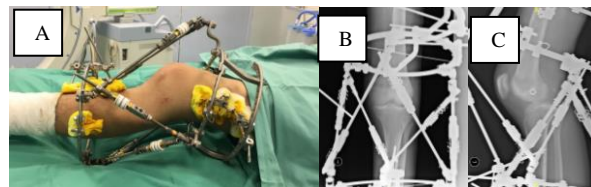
Post operative knee photograph and plain radiographs of one of the patients. (A) Ortho-SUV frame applied in-situ across the dislocated knee. (B) AP view and (C) lateral view plain radiographs demonstrating the posterior knee dislocation.
